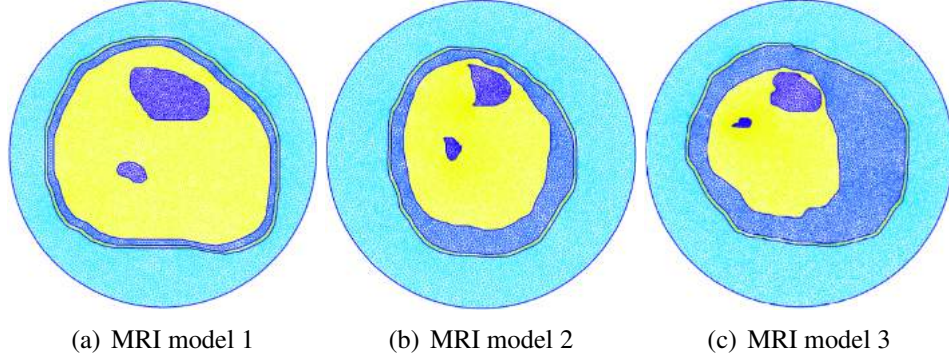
Triangular meshes generated by GMSH of the three MRI images.
